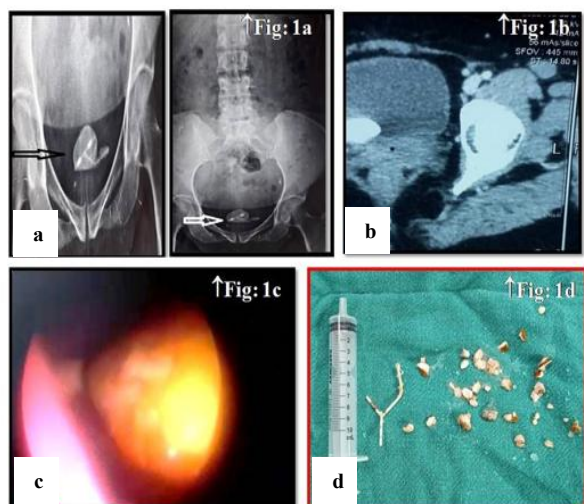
(a) Radio-opaque shadow within bladder, (b) CT image of same, (c) cystoscopic view of the intravesical IUD calculus and (d) external extracted intravesical view of the IUD foreign body.
